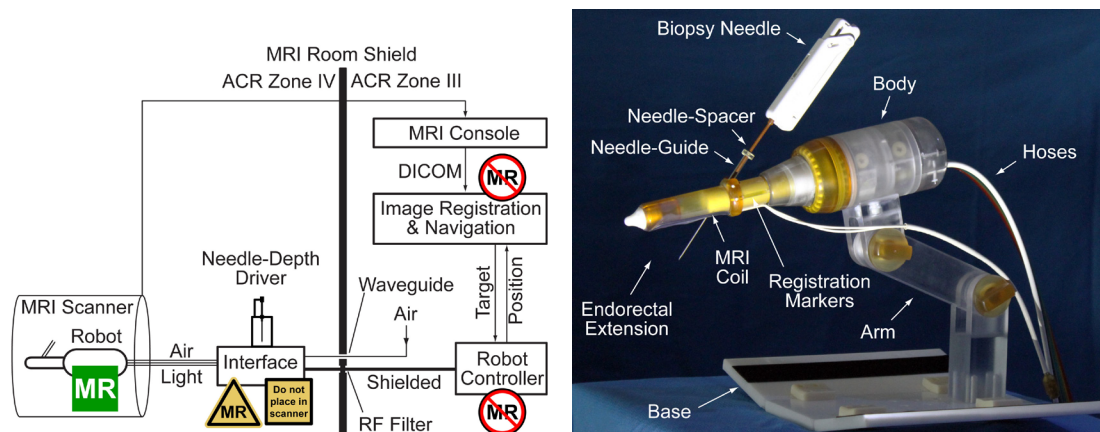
MRI-Safe robot system
